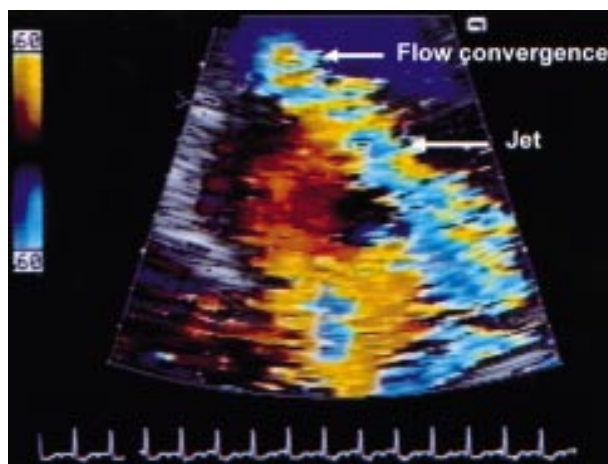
Echocardiographic long axis apical view of the left atrium with colour flow imaging of the jet of mitral regurgitation in a patient with flail posterior leaflet. Note the eccentric jet occupying only a portion of the left atrium despite the severe regurgitation with a large proximal flow convergence.
